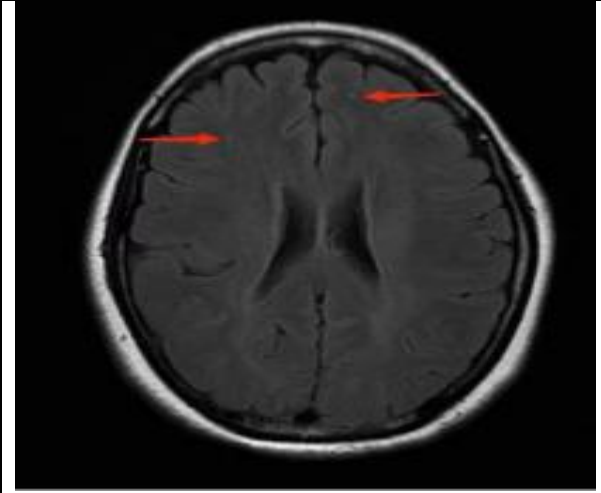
A bilateral modest ischemia centre in the frontal lobes was visible on an MRI T2 flare.
